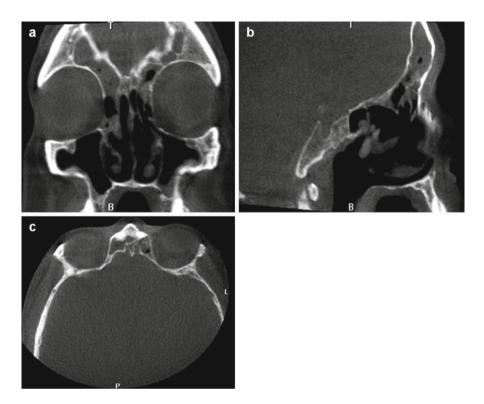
Patient with chronic rhinosinusitis with nasal polyposis having undergone previous endoscopic sinus surgery. (a) Coronal (b) sagittal and (c) axial CT scan demonstrates extensive frontal sinus disease contributing to the overall inflammatory burden of disease
